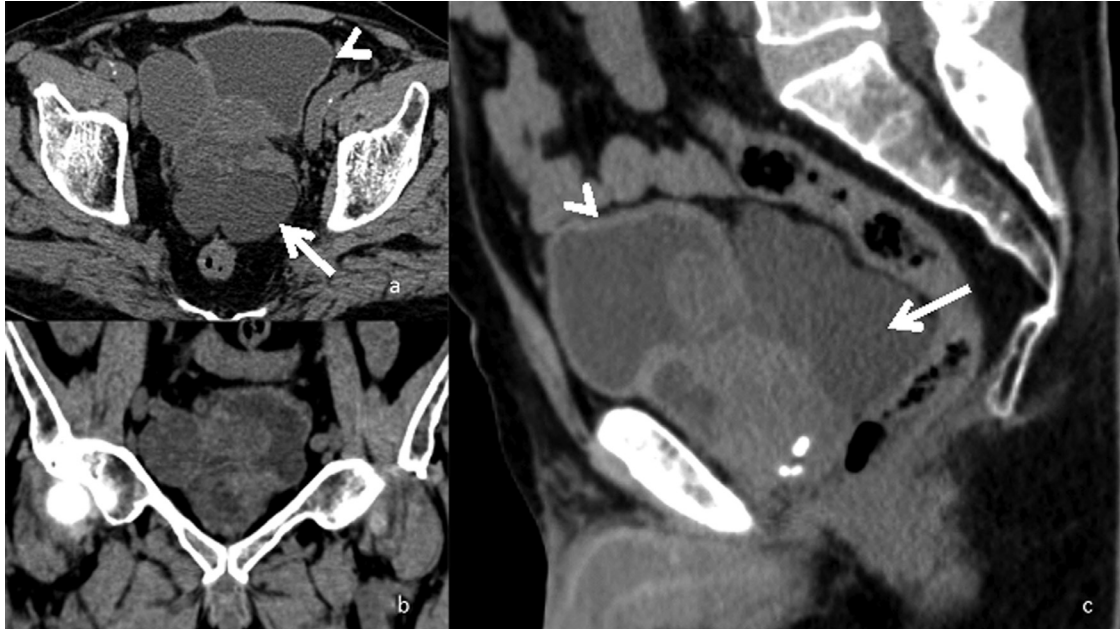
An unenhanced Computed Tomography (CT) scan of the abdomen and pelvis (A: axial; B: coronal; C: sagittal) showing a large multiloculated mass (*arrow*) arising from the prostate gland and measuring around 12 × 6.7 × 5.2 cm in its AP, transverse and craniocaudal dimensions respectively. The seminal vesicles are entrapped within this multilocular cystic lesion. The mass is seen extending anterior toward the abdominal wall and pushing the bladder (*arrowhead*) laterally. Posteriorly, the mass is seen almost abutting on the rectum.
